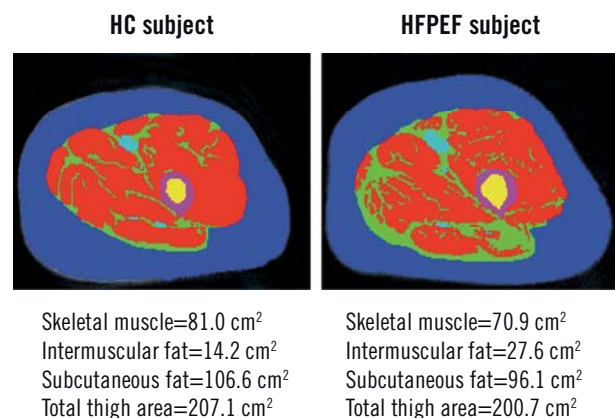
MRI axial image of the midthigh in a patient with HFPEF and in a HC subject. The red color indicates skeletal muscle, blue is subcutaneous fat, and green is intermuscular fat. The latter is substantially increased in the patient with HFPEF compared with the HC despite similar subcutaneous fat.
